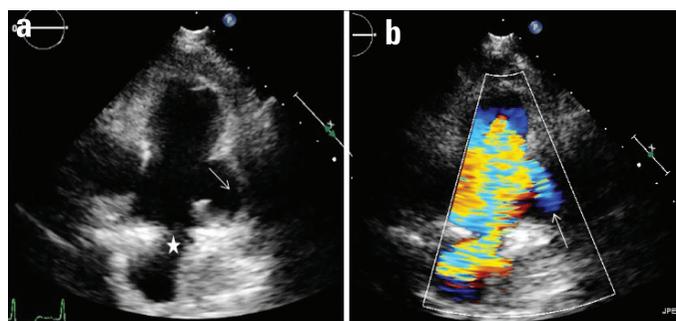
(a) Two-dimensional transthoracic echocardiography showed the patent ductus arteriosus (asterisk) and the pseudoaneurysm (arrow). (b) Color Doppler echocardiography demonstrated the blood flow from the pulmonary artery into the pseudoaneurysm (arrow)
